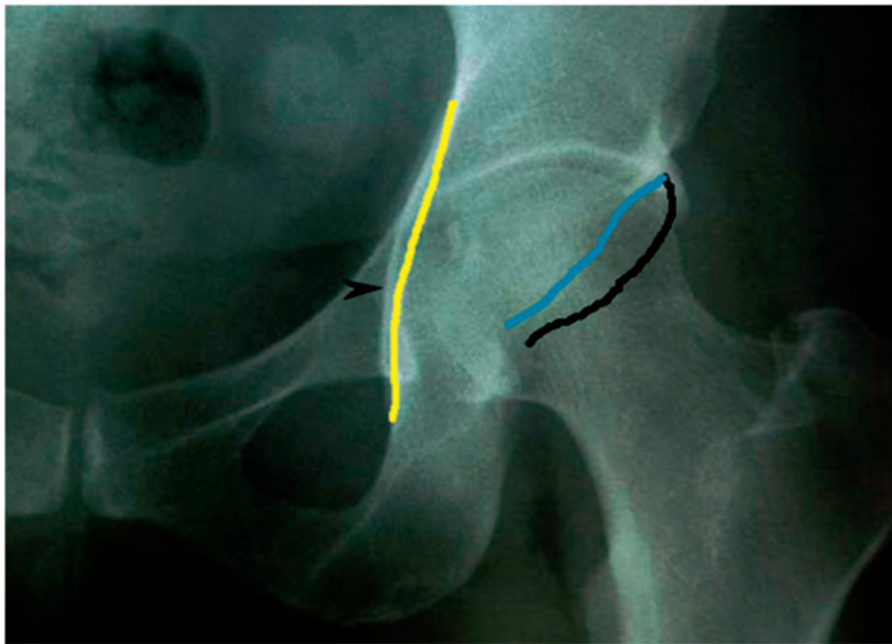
Representative radiographic findings of global pincer subtype. Note the margins of the anterior (blue line) and posterior (black line) walls with the anterior rim passing through and the posterior rim lateral to the center of the femoral head without a crossover sign. The acetabular fossa floor is medial to the ilioischial (yellow) line consistent with true coxa profunda with a CEA of 43 degrees.
